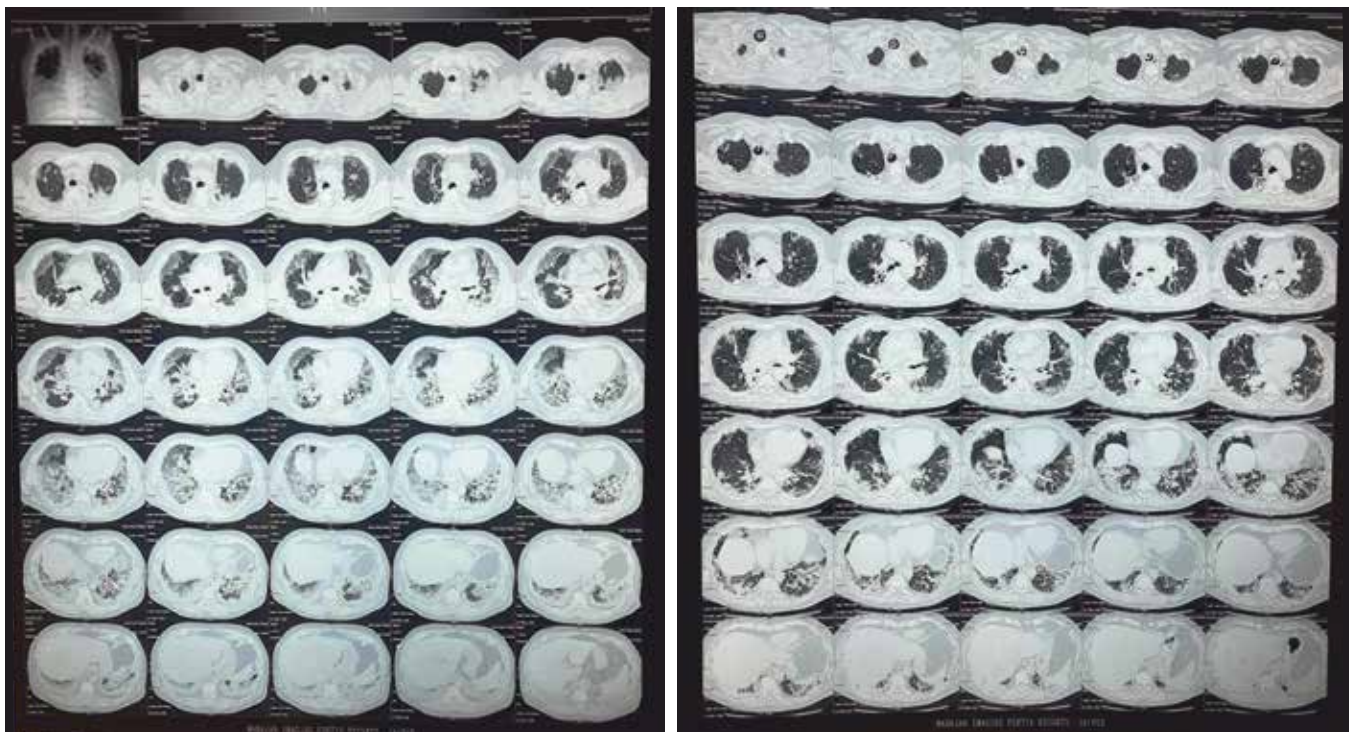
Comparative HRCT scans of the patient at the time of admission and on 7<sup>th</sup> day of admission. There is reduction in areas of consolidations and ground glass opacities noted with reduction in pleural effusion noted.
